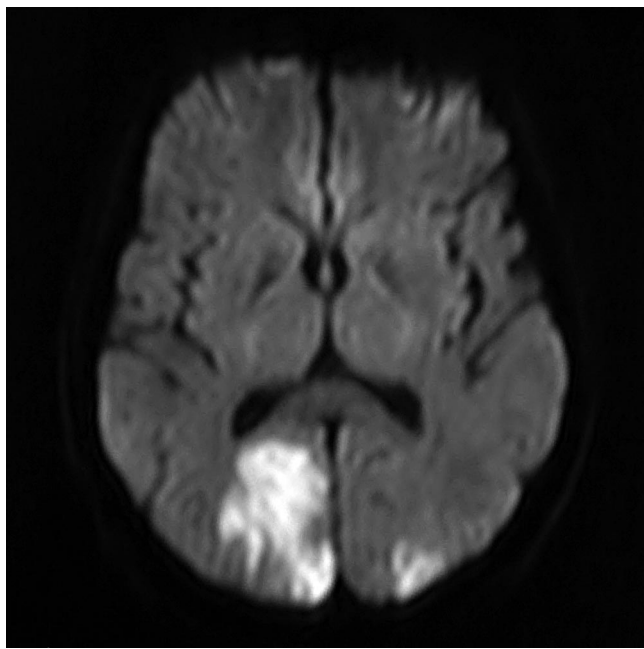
Magnetic resonance image of head with abnormal diffusion signal in the occipital lobes bilaterally, characteristic of ischemia.
